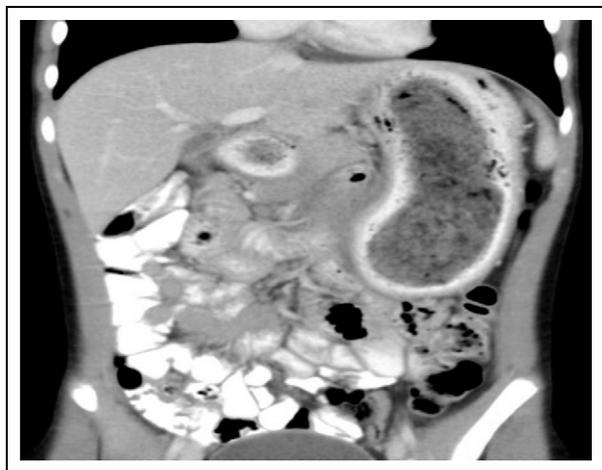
Computed tomograph of the abdomen showing heterogeneous mass in the stomach with mottled air pattern and oral contrast material surrounding the mass in a patient with gastric bezoar.
